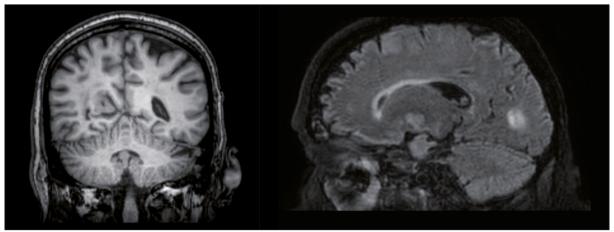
T3 gadolinium-enhanced brain MRI showing Toxoplasma gondii lesions, T1 (left) and T2 (right).
